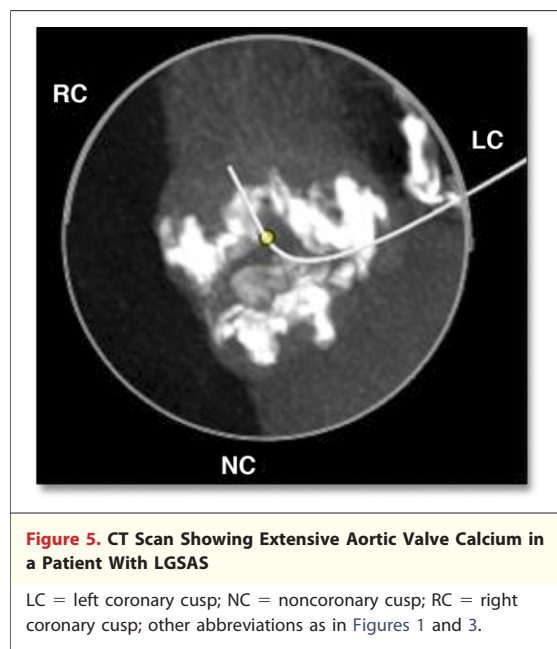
CT Scan Showing Extensive Aortic Valve Calcium in a Patient With LGSAS
